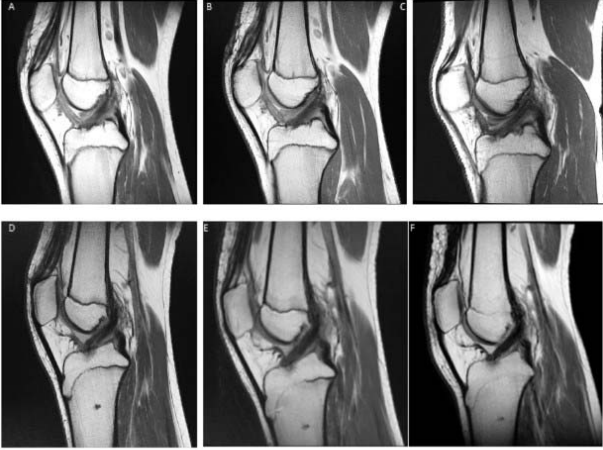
Example of sagittal MRI Images at 6-months, 1-year, and 2-years postoperatively in a patient who underwent ACLR-only (A through C) and ACLR+LET (D through F).
